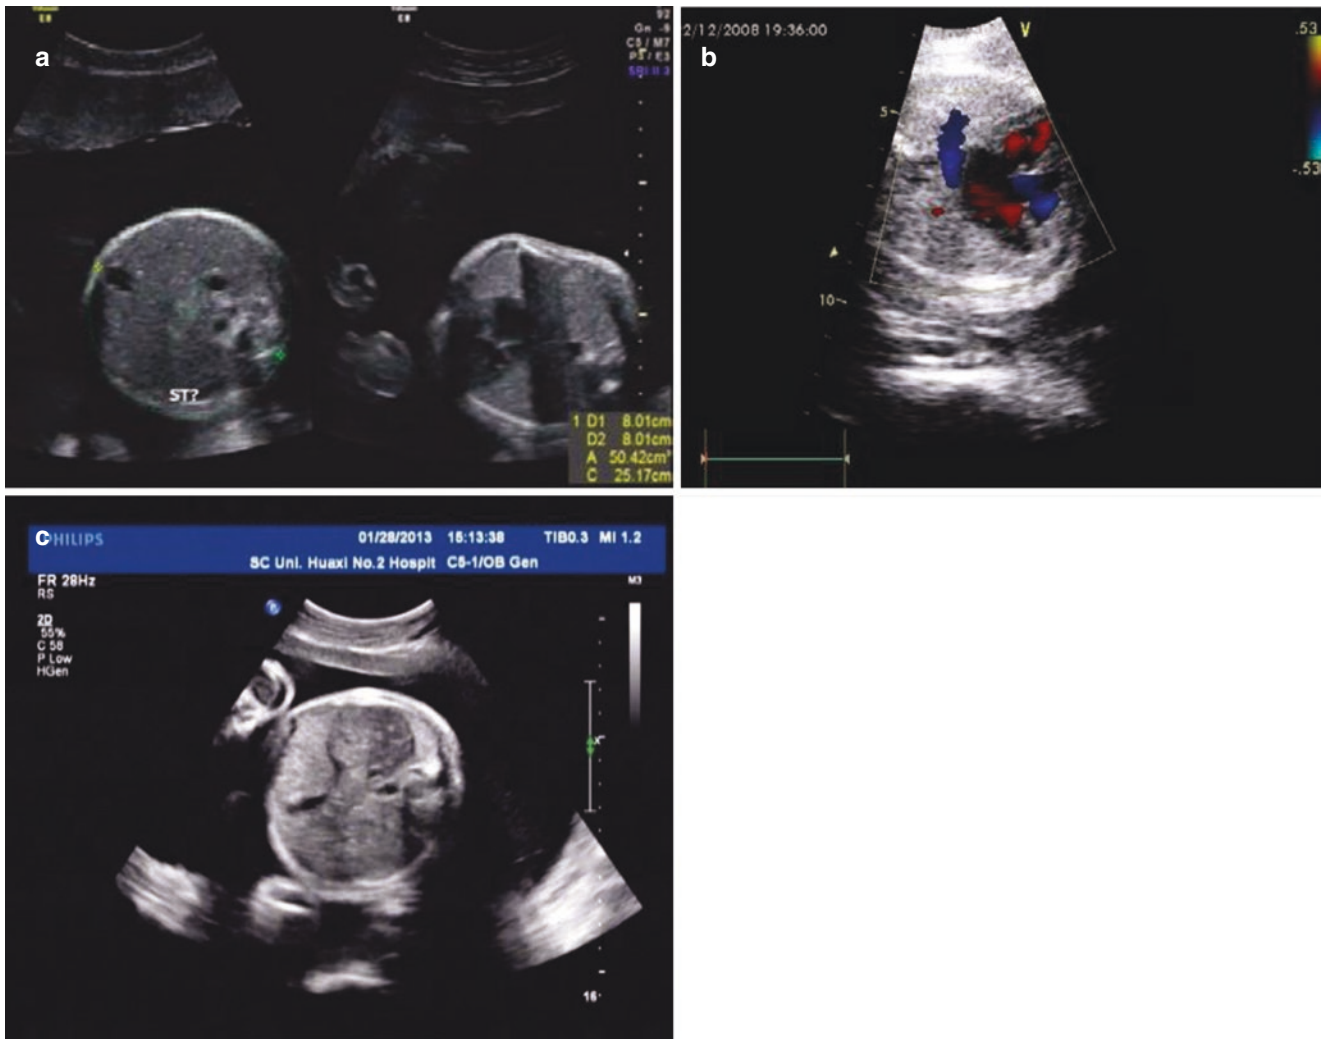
Esophageal atresia. (a, b). The image shows no stomach bubble in the abdominal cavity with polyhydramnios at 28 weeks of gestation. Fetal echocardiography shows an atrial septal defect. (c). An absent stomach bubble with polyhydramnios at 35 weeks of gestation. The fetus died from digestive tract atresia after birth
